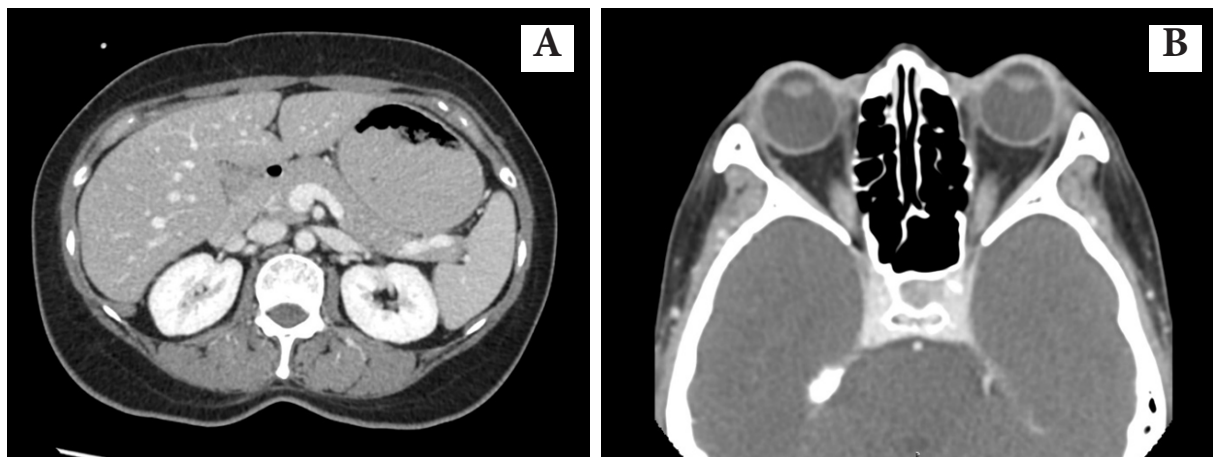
After three cycles of chemotherapy (CHOP regimen) in a case of MALT lymphoma. Conventional CT of the whole abdomen axial (A) shows disappearance of multiple well-defined enhancing nodules along the subcutaneous layer of the abdominal wall. Conventional CT of the orbit in axial (B) shows disappearance of multiple enhancing masses involving both lacrimal glands, upper eyelids, and the intra/extra-conal spaces of both orbits.
